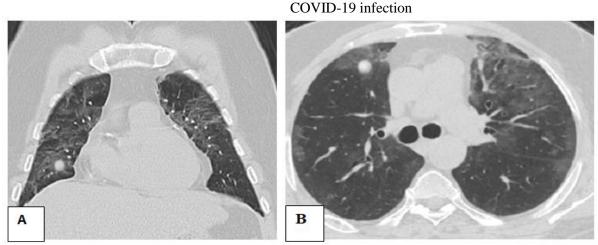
58-years old male patient, having history of cancer colon referred for RF ablation of solitary metastatic right middle lobar pulmonary nodule coming for RF ablation. (A) and (B) axial and coronal CT chest imaging respectively shows bilateral sub-pleural pulmonary consolidations and ground-glass opacities (CORADS 5)
